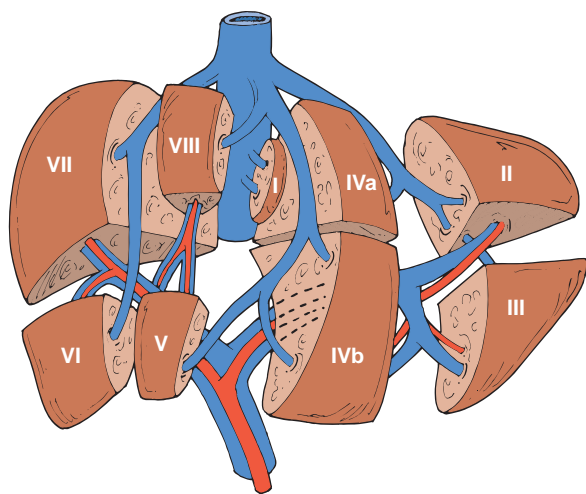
Segments of the liver as described by Couinaud. (From Meire H, Cosgrove D, Dewbury K, Farrant P: *Clinical Ultrasound: A Comprehensive Text—Abdominal and General Ultrasound*, vol 1, 2nd ed. London, Churchill Livingstone, 2001, p 167.)
